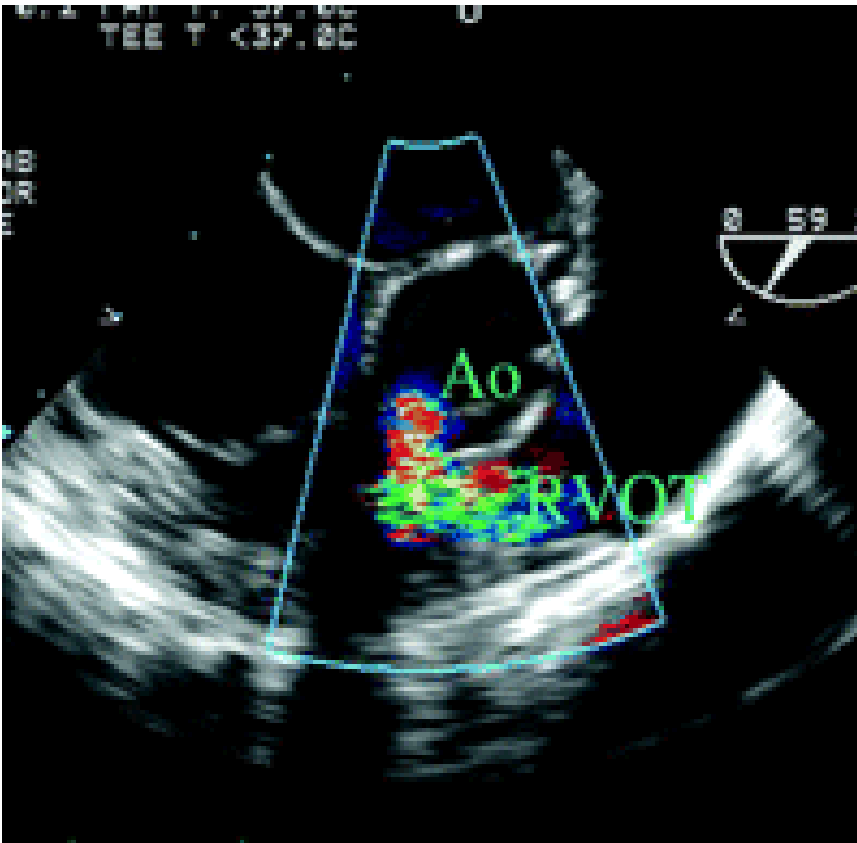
Subaortic high-membranous VSD with flow into the right ventricular outflow tract (RVOT) from interpretative trans-oesophageal echocardiogram. Ao indicates Aorta.
